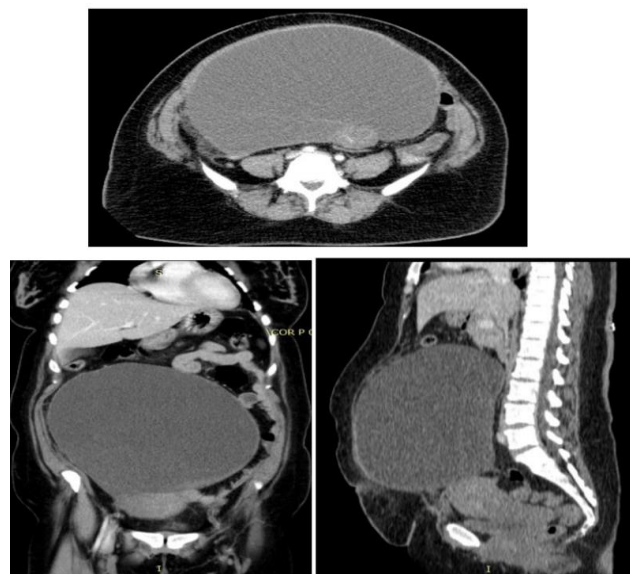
Axial, coronal & sagittal CT sections of abdomen and pelvis with IV contrast.
